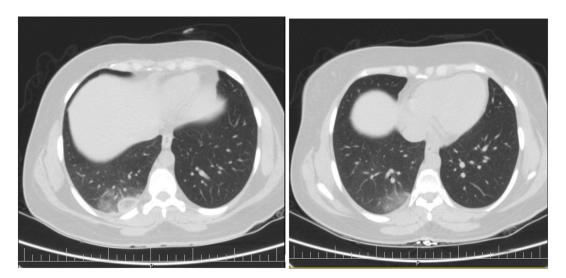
Patient's abdominopelvic CT scan indicating the involvement of the base of right lung.
